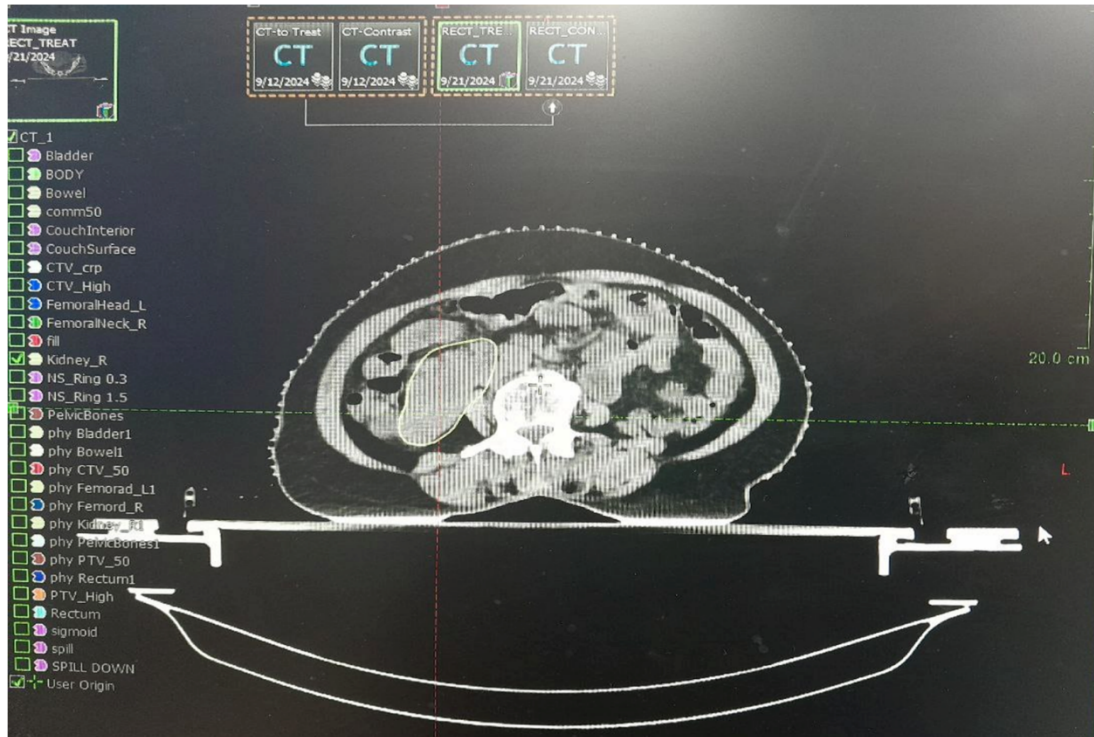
Fused kidney as seen on planning CT (Axial section)
